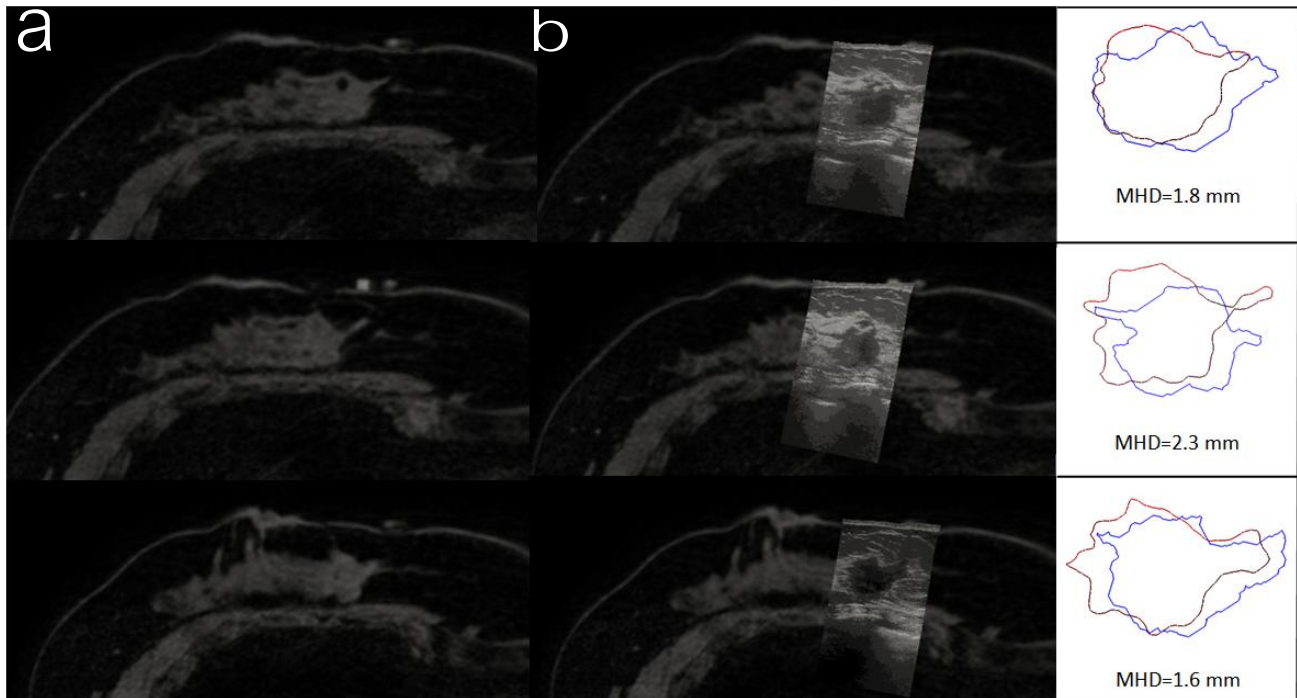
Column (a) is three supine MR slices, Column (b) shows three different registered ultrasound slices overlaid on the corresponding MR slice. The third column shows MR contours (red) and corrected US contours (blue) as well as the MHD values for the two contours.
